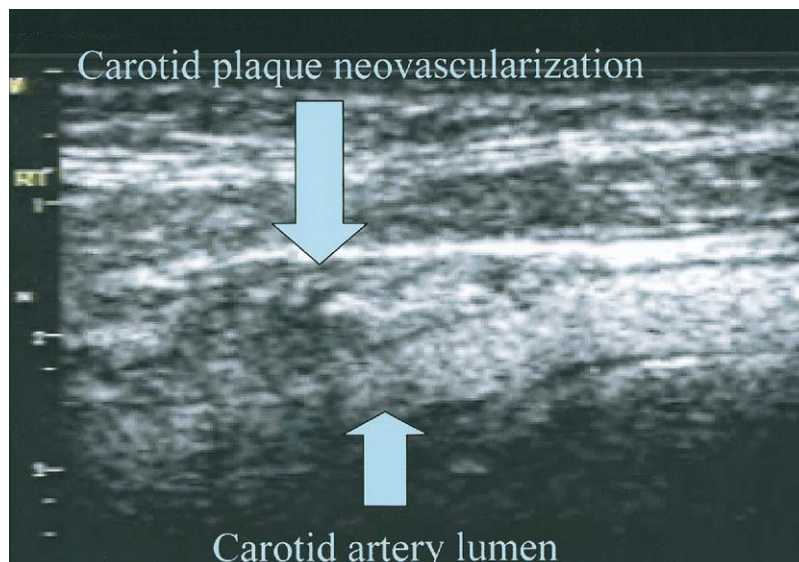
The presence of intraplaque angiogenesis is highlighted by the use of ultrasound contrast agents. The image was obtained during an ultrasound examination of a patient who had a history of a transient ischemic attack.
